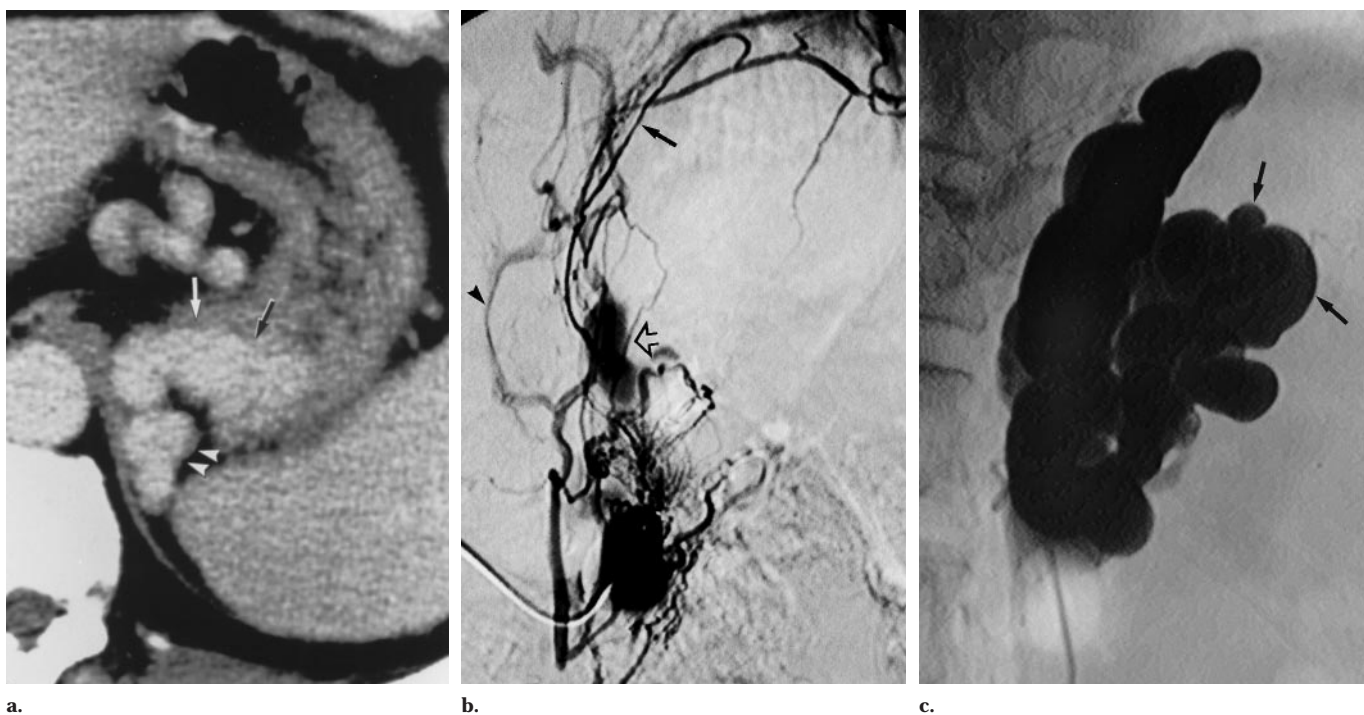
Grade 3 gastric varices and collateral veins in a 62-year-old man who had huge gastric fundal varices, 8 cm in diameter according to endoscopic measurement. (a) CT scan shows marked dilatation of gastric varices (arrows), which are connected with the dilated gastrorenal shunt (arrowheads). (b) Left adrenal angiogram obtained during balloon occlusion shows the inferior phrenic vein (solid arrow) and dilated paravertebral veins (arrowhead), but gastric varices (open arrow) are only partially visible. Injection of 30 mL of the ethanolamine oleate–iopamidol mixture into the veins terminated the first balloon-occluded retrograde transvenous obliteration procedure. (c) Angiogram from second angiographic study performed 2 weeks after the first shows complete depiction of the gastric varices (arrows) and occlusion of the collateral veins; 30 mL of the ethanolamine oleate–iopamidol mixture was injected with balloon occlusion. One month after the second balloon-occluded retrograde transvenous obliteration procedure, the gastric varices were completely obliterated.
